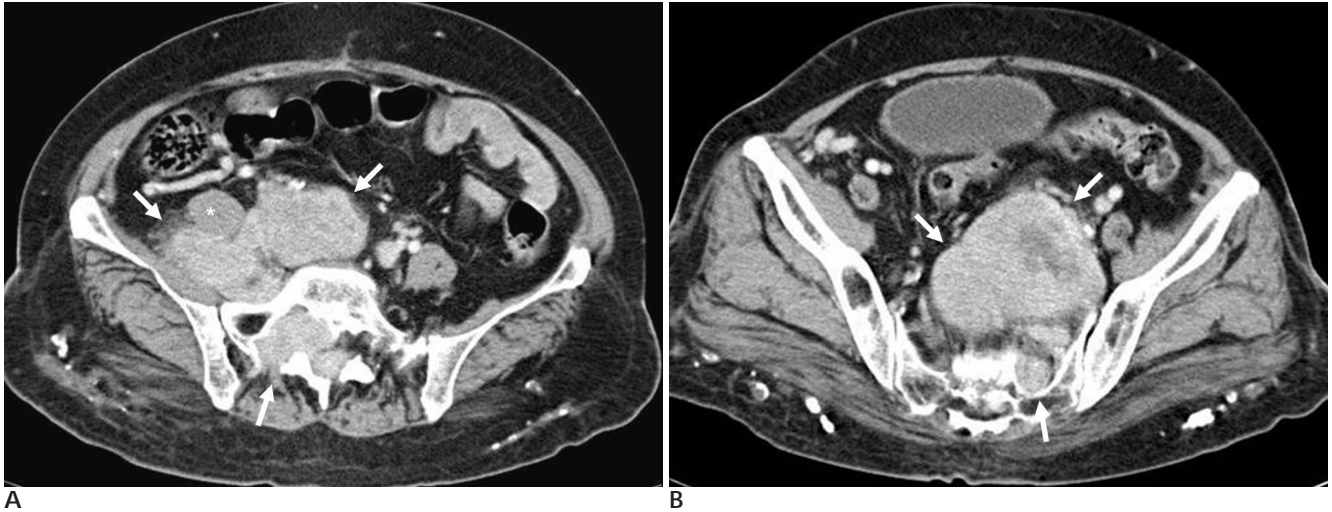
A, B. The contrast enhanced CT scan shows a lobulated, homogeneously enhancing, soft tissue mass in the right S1 paravertebral region, the pelvic cavity and within the spinal canal together with vertebral body erosion (arrows). This lesion is displacing the right psoas muscle () anterolaterally.
